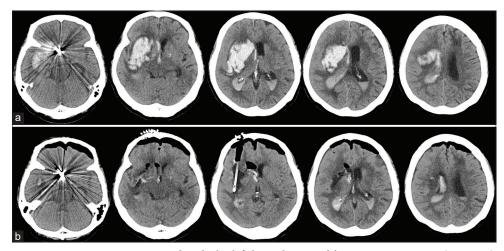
Representative case: a 79 woman presented with the left hemiplegia, and her GCS score was 7 (E2V1M4) on admission. The preoperative CT showed 75 mL of the right putaminal hemorrhage (a). Endoscopic hematoma removal with a trans-forehead approach was performed. Postoperative CT showed 3 mL of the rest, and the hematoma removal rate was 96% (b).
